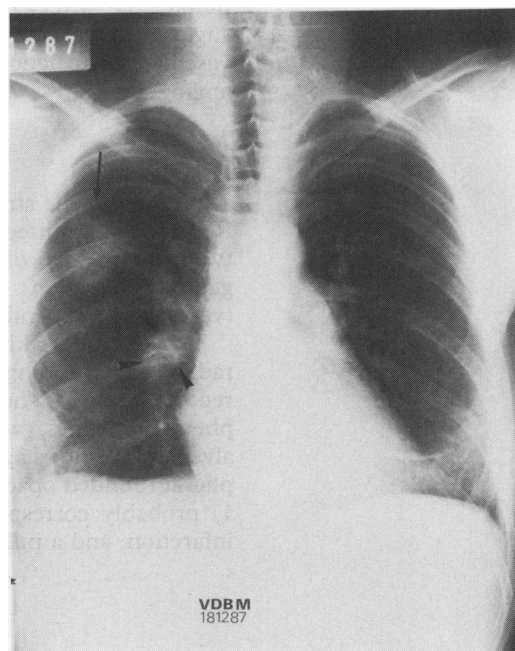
Posteroanterior chest radiograph showing an infiltrate in the right upper lung field (arrow) and a round opacity near the right hilum (arrow heads). A linear shadow in the left lower lung field and an ill defined infiltrate in the right lower lung field are the remains of previous thromboemboli.
